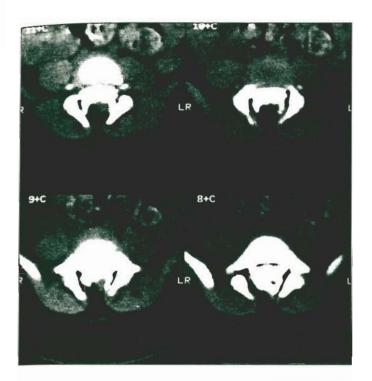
Tethered cord with lipoma. Axial CT following myelography (figure 5) demonstrates spinal dysraphism involving the lower lumbar spine and sacrum. The spinal cord extends to the L4 level. The thickened filum terminale lies to the left of the midline. There is fat within the spinal canal that extends posteriorly and slightly to the right to merge with the fat in the buttocks.
